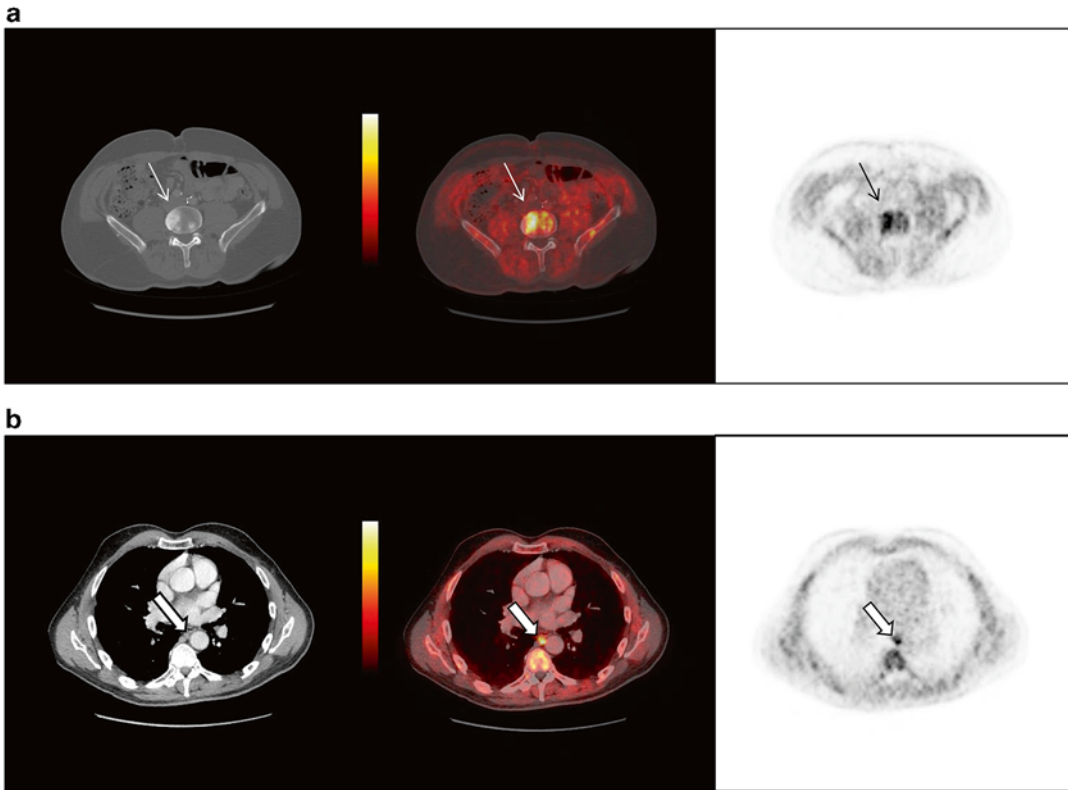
A 64-year-old male with metastatic CRPC imaged with anti- ^{18}F -FACBC PET/CT demonstrates (a) a L4 vertebral body bone metastasis and (b) small paraesophageal nodal metastasis
